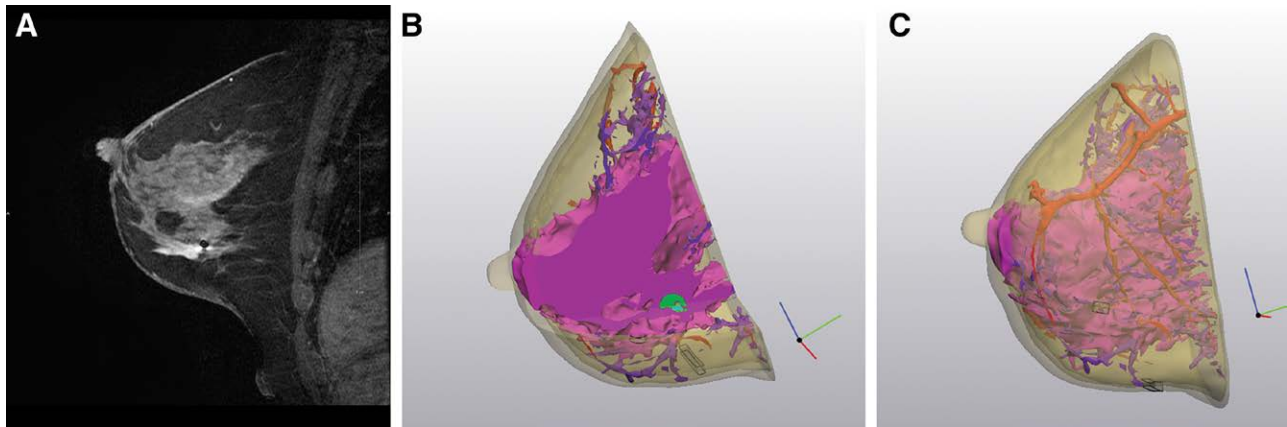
Breast MRI and associated three dimensional model, for preoperative planning of nipple sparing mastectomy. A, MRI of preoperative patient with a 1-centimeter invasive ductal carcinoma in the lower, inner quadrant. B, Three-dimensional computer model with tumor in green and biopsy clip in blue. C, Computer model with second intercostal perforating artery, from the internal mammary artery, running through the anterior lamellar fat to the nipple.
